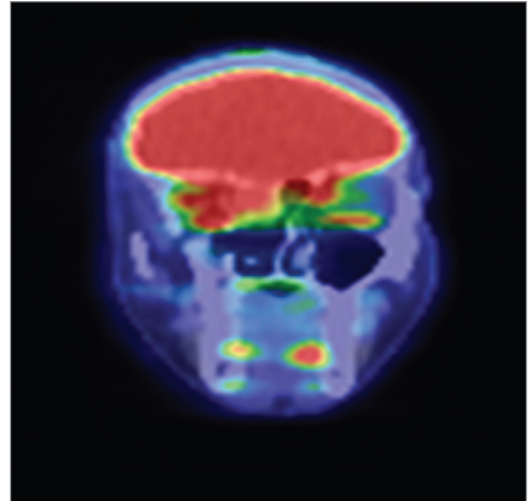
A, Postintravenous contrast computed tomographic (CT) scan of the face showing a relatively homogenous mass of the right ethmoid complex with invasion of the orbit and extension to the nasal cavity (arrowhead). B, Fast spin echo (FSE) T2 magnetic resonance image (MRI) of the right ethmoidal/orbital soft-tissue mass (arrowhead). C, Positron emission tomographic (PET) scan of the face with fludeoxyglucose F 18 showing increased uptake within the right ethmoid air cells and nasal cavity, and in the medial right orbit.
